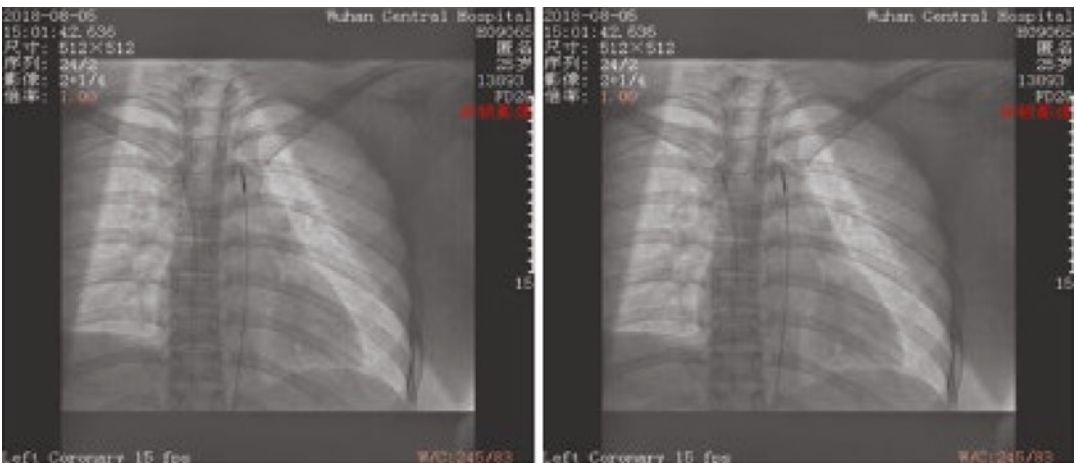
The chest radiographs show that the heart shadow is small
